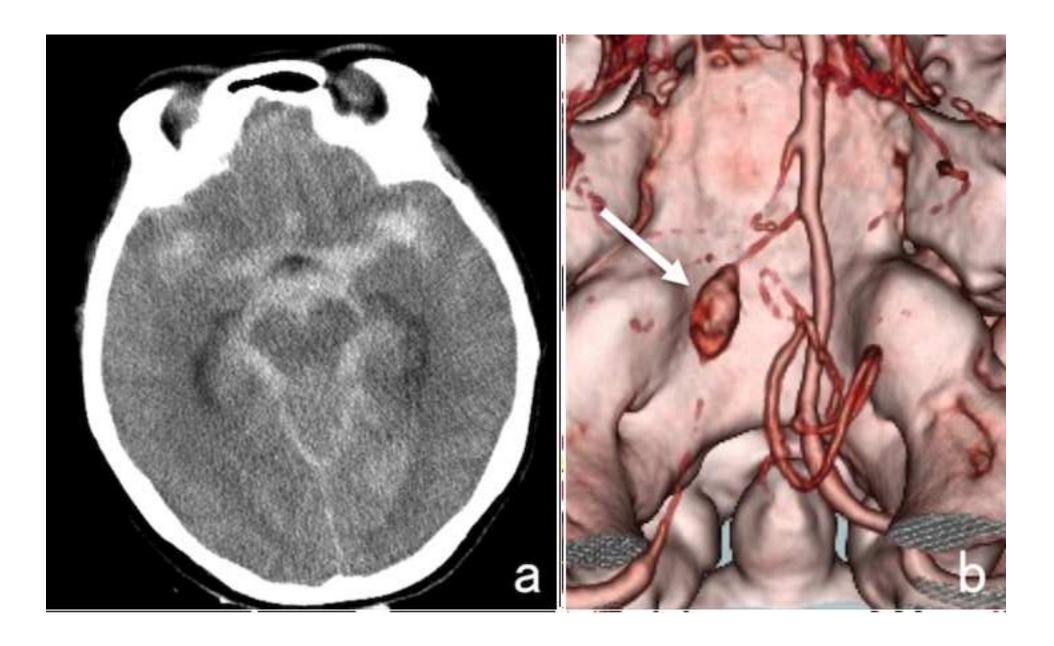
a) Brain CT demonstrated typical subarachnoid hemorrhage. b) 3-dimentional CT angiography showed a dilatation (arrow) and narrowing of left vertebral artery, indicating a vertebral artery dissecting aneurysm
